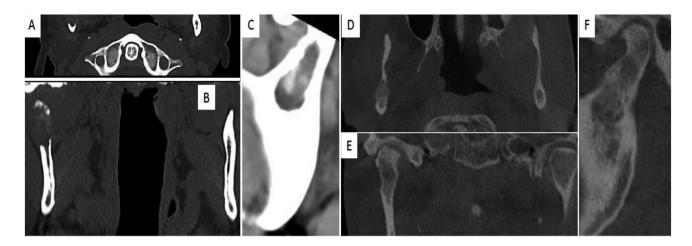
Slice images of the jaws with computed tomography (A-C) and cone beam computed tomography (CBCT) (D-F) (cropped images). (A-C) The CT was taken at the time of the initial diagnosis and shows the skull base in the border area of the field of view. (A) The axial layer shows the incisure of both mandibular sides. The right side of the jaw has a sharply defined, bowl-shaped, bi-cortical osteolysis. (B) The vertical dimension of the osteolysis becomes clear in the coronal view. (C) In sagittal projection, the central defect is partially circumscribed by cortical bone. CBCT was performed seven months after chemotherapy. (D) The axial image shows the hyperdense filling of the bone defect. This filling has a suggested oval outline and a density like bone. (E) The coronal image reveals the irregular surface of the hyperdense defect filling. Compare the contour of the vestibular bone surface on MRI with the bone surface image on ultrasound in Figure 4. (F) The sagittal image shows the inhomogeneous hyperdensity within the defect filling.
